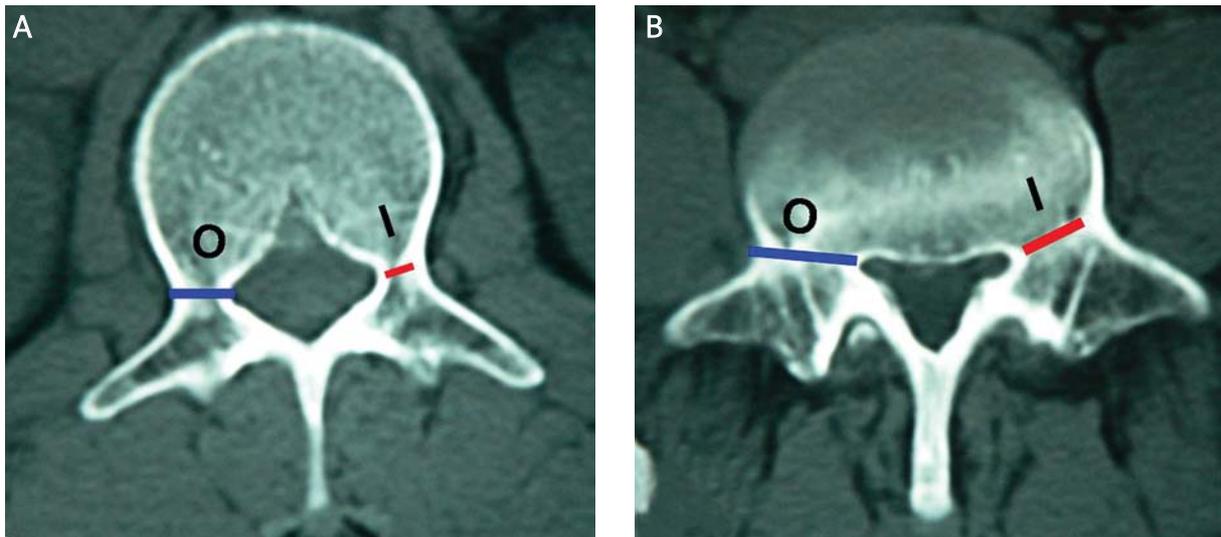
(A) Transverse sectioned CT of L1 vertebra demonstrates: I – the inner diameter of the left pedicle, O – the outer diameter of the right pedicle; (B) transverse sectioned CT of L5 vertebra demonstrates: I – the inner diameter of the left pedicle, O – the outer diameter of the right pedicle
